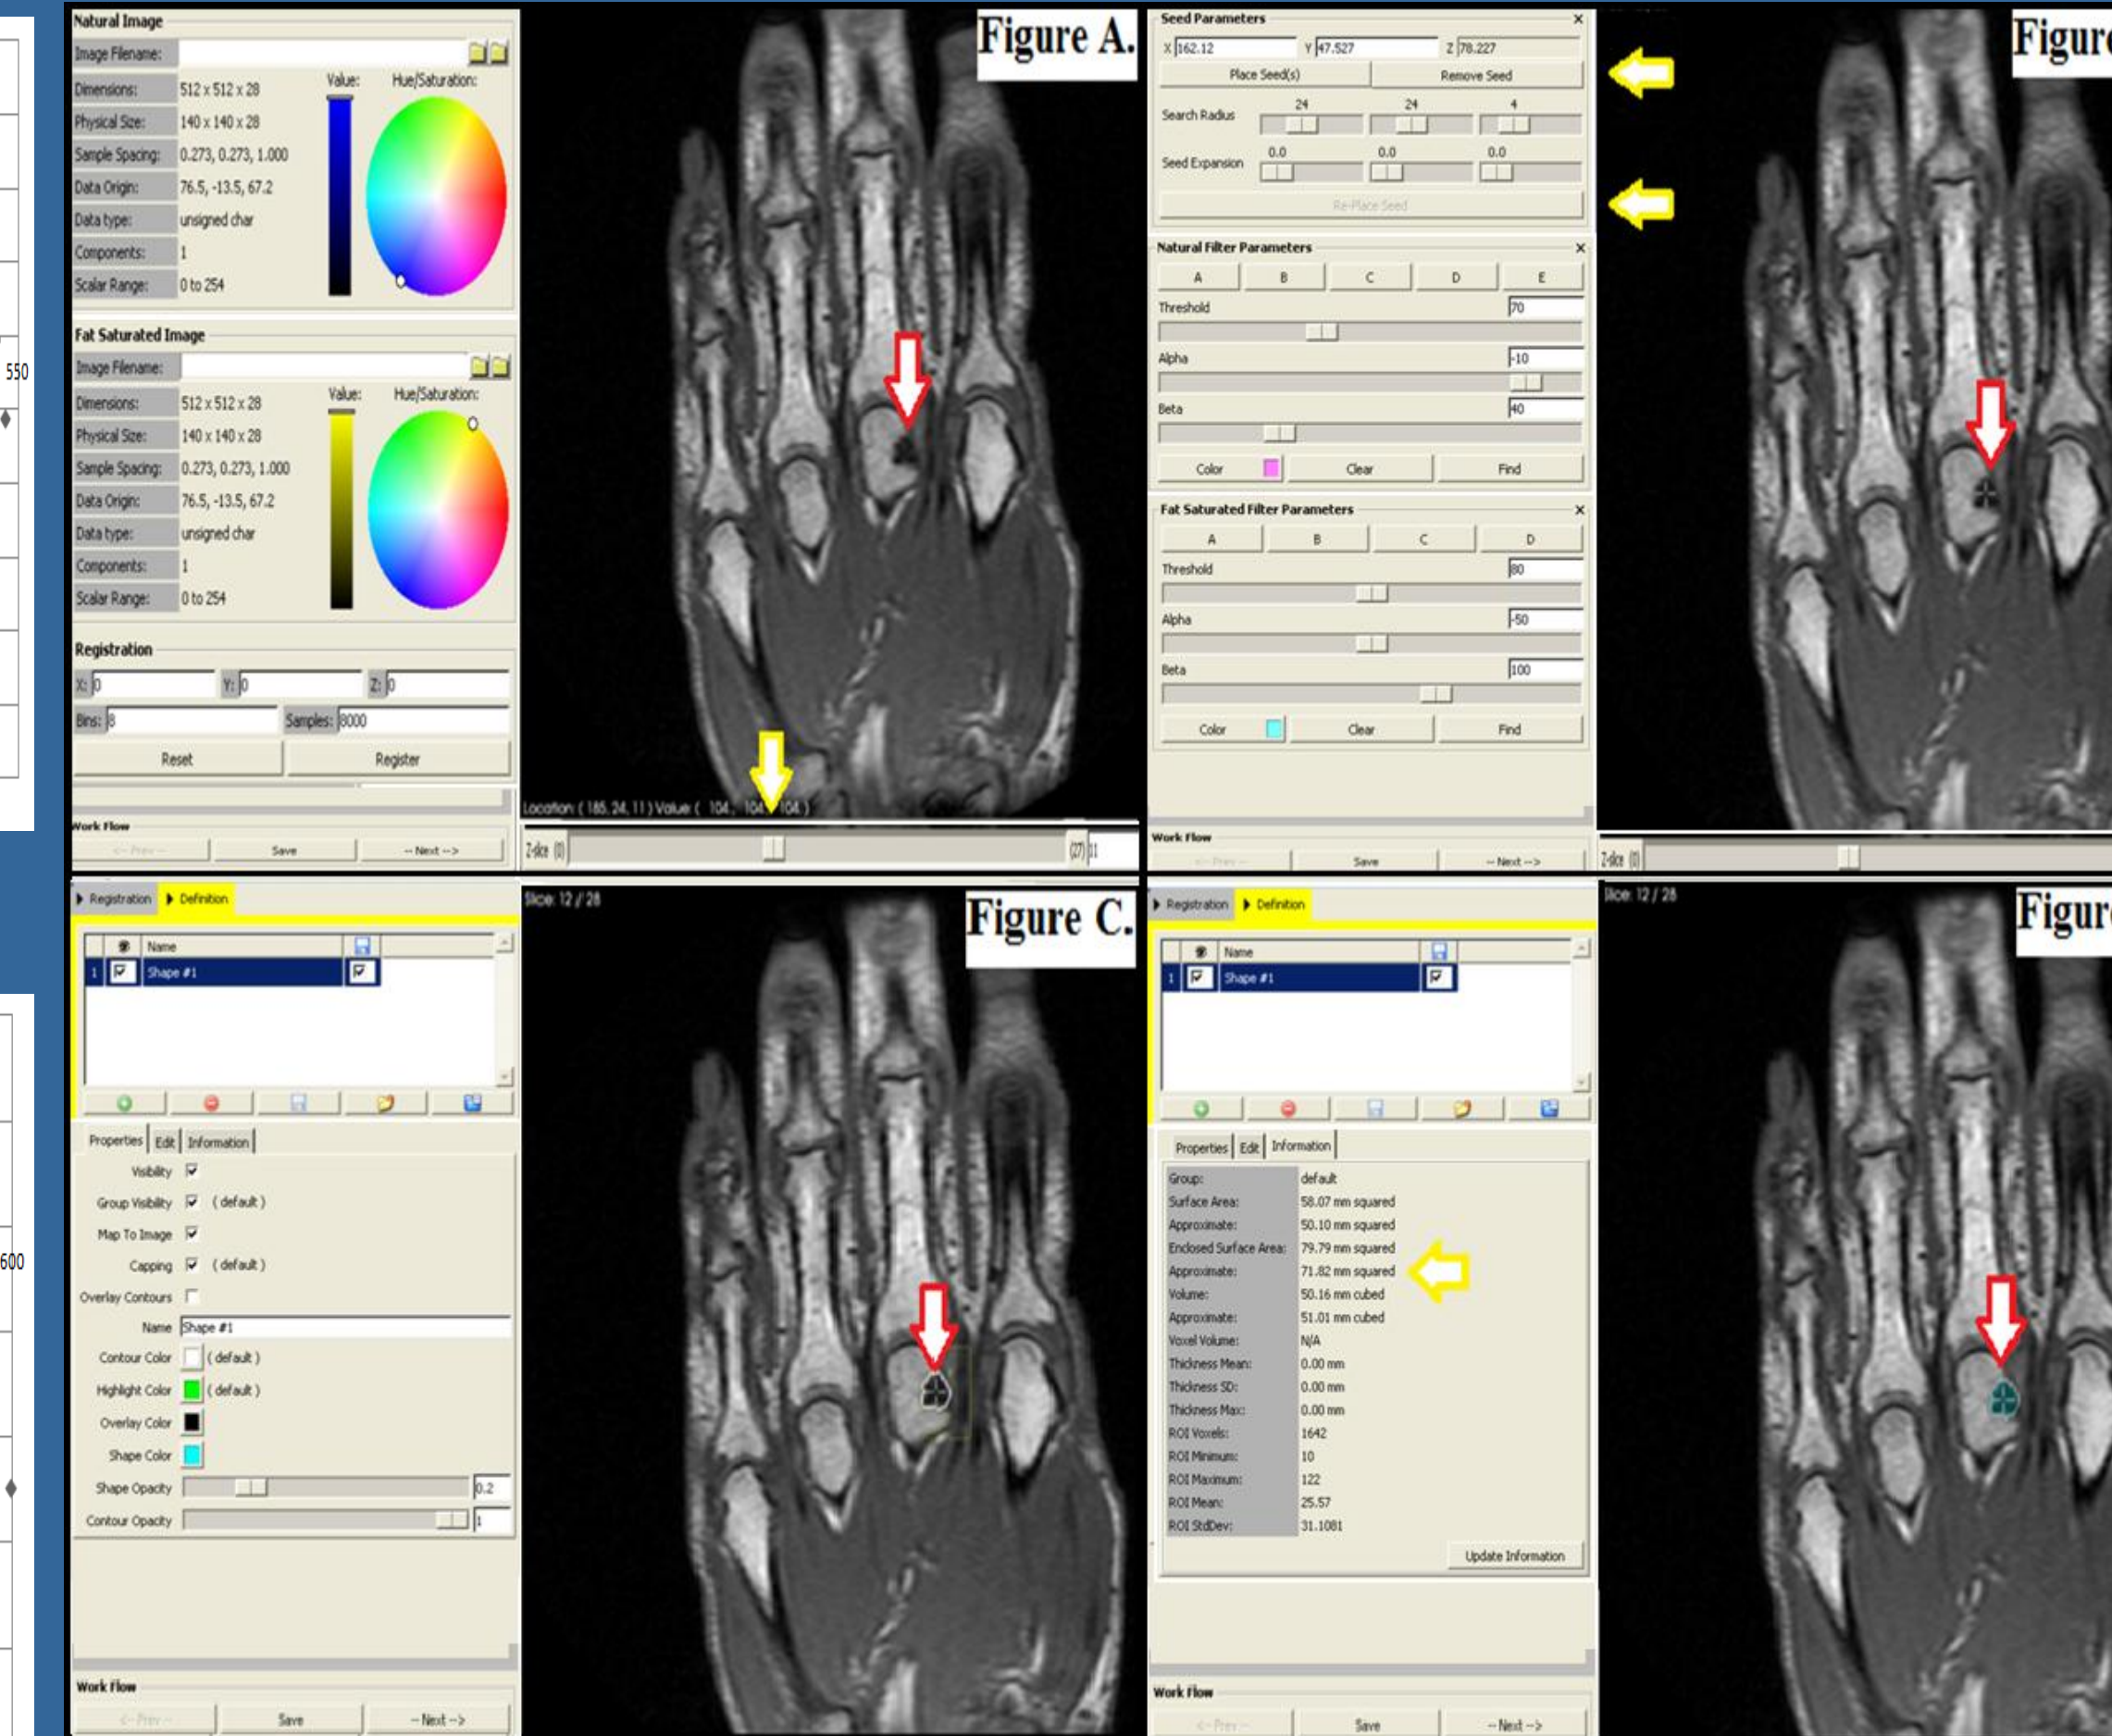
Readers opened the MR image on the EERA software and manually chose the image slide for seeding, (Figure A). Readers placed the seed point near the middle of the erosion and then automatically re-run the seeding until stabilization is achieved (Figure B). Readers manually chose from one of the five potential software parameters labeled A to E that best fits the contours of the bone erosion (Figure C). The EERA software then generates a total volume score of the erosion (Figure D).
